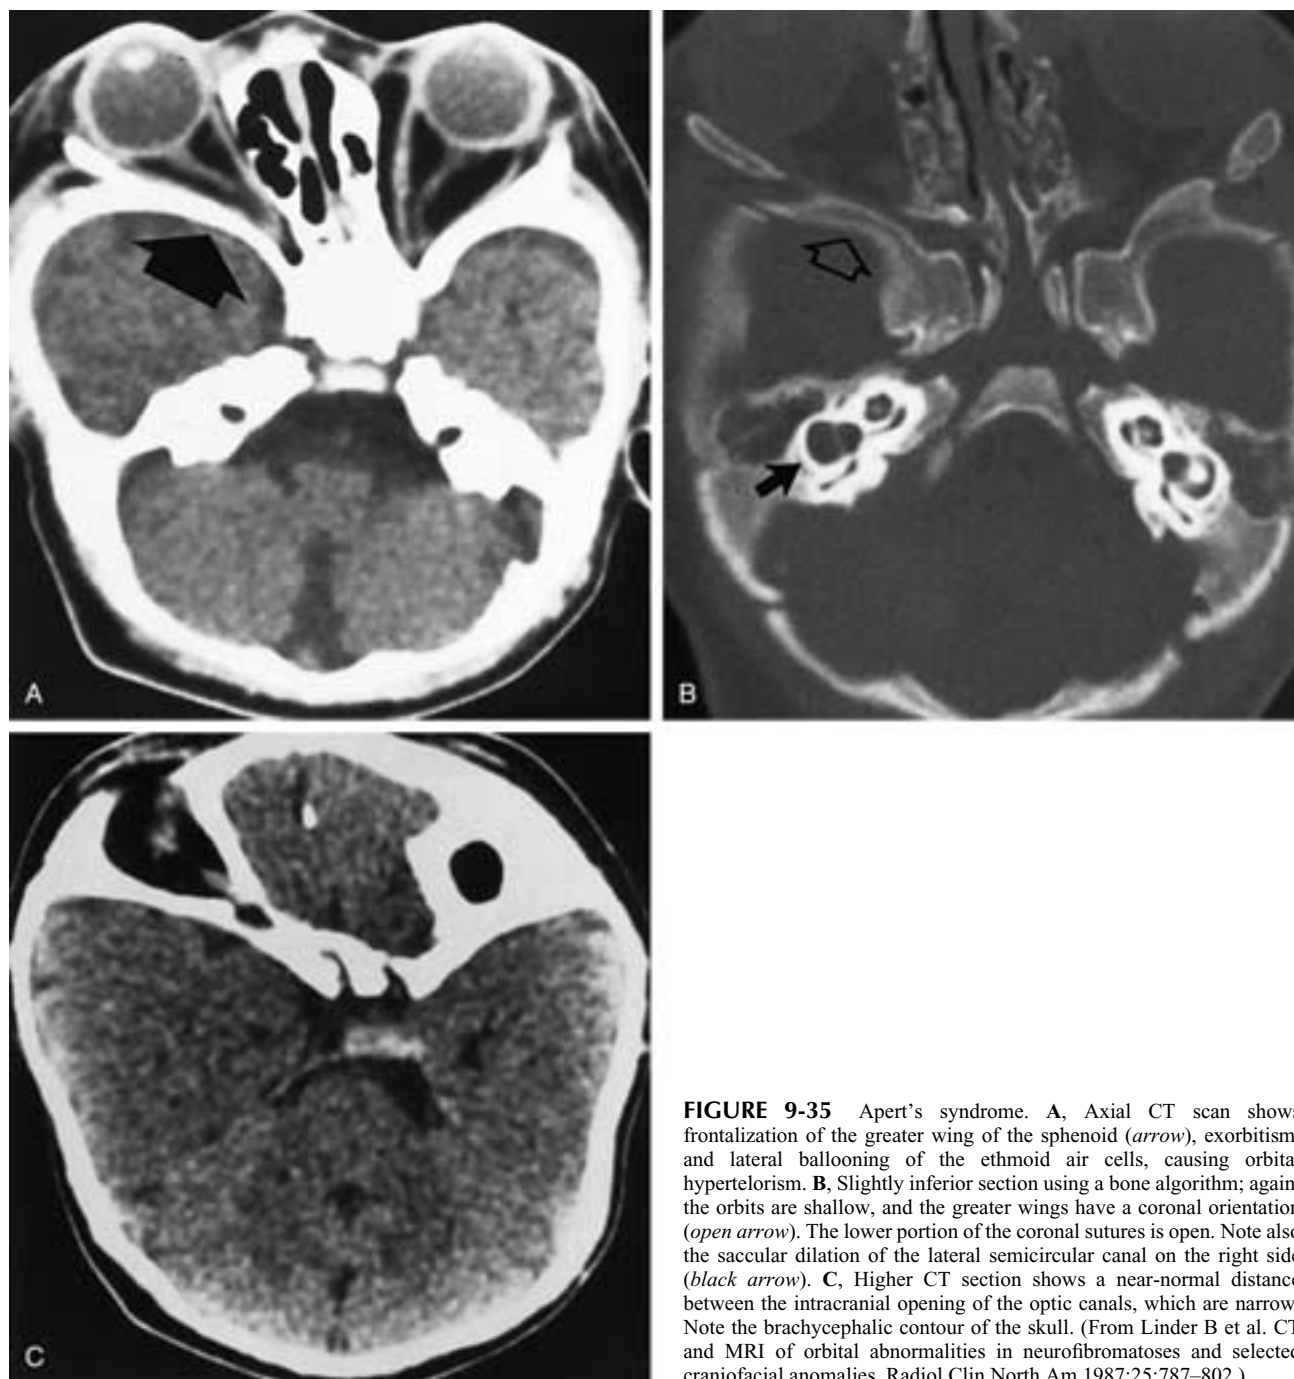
Apert's syndrome. A, Axial CT scan shows frontalization of the greater wing of the sphenoid (*arrow*), exorbitism, and lateral ballooning of the ethmoid air cells, causing orbital hypertelorism. B, Slightly inferior section using a bone algorithm; again, the orbits are shallow, and the greater wings have a coronal orientation (*open arrow*). The lower portion of the coronal sutures is open. Note also the saccular dilation of the lateral semicircular canal on the right side (*black arrow*). C, Higher CT section shows a near-normal distance between the intracranial opening of the optic canals, which are narrow. Note the brachycephalic contour of the skull. (From Linder B et al. CT and MRI of orbital abnormalities in neurofibromatosis and selected craniofacial anomalies. *Radiol Clin North Am* 1987;25:787–802.)
